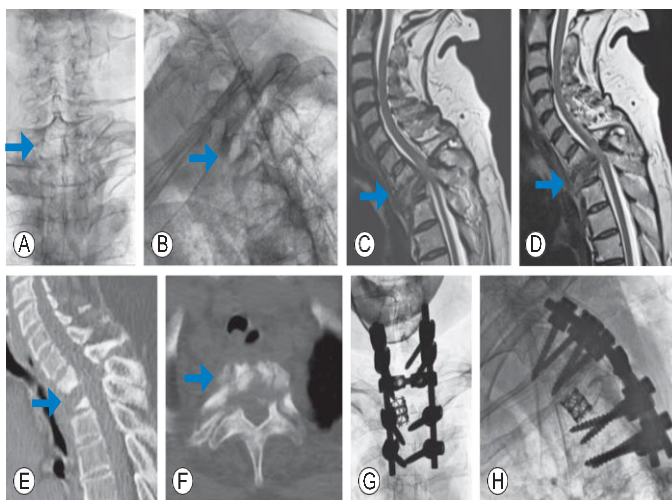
X-rays (A, B) and MRI (C, D) and CT scan (E, F) of a patient before and after posterior stabilization and transpedicular decompression by pediclectomy, followed by corpectomy and anterior reconstruction via mesh cage. As shown by the direction of the arrows, the pathology is located in the highlighted region.
